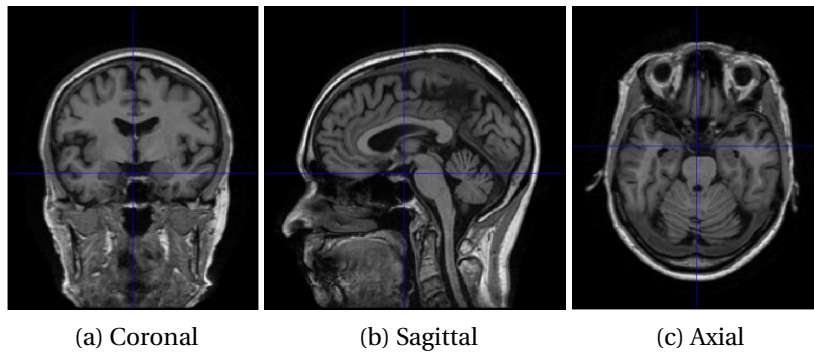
T1-weighted MRI image of the three anatomical planes.
